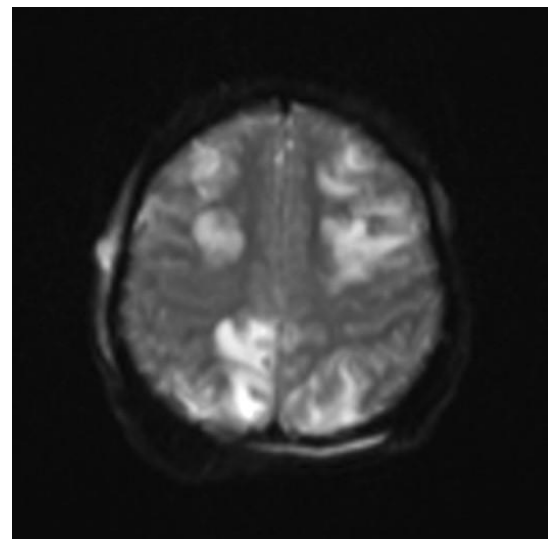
4 Axial (DWI)image showing restriction in fronto parietal lobes.
